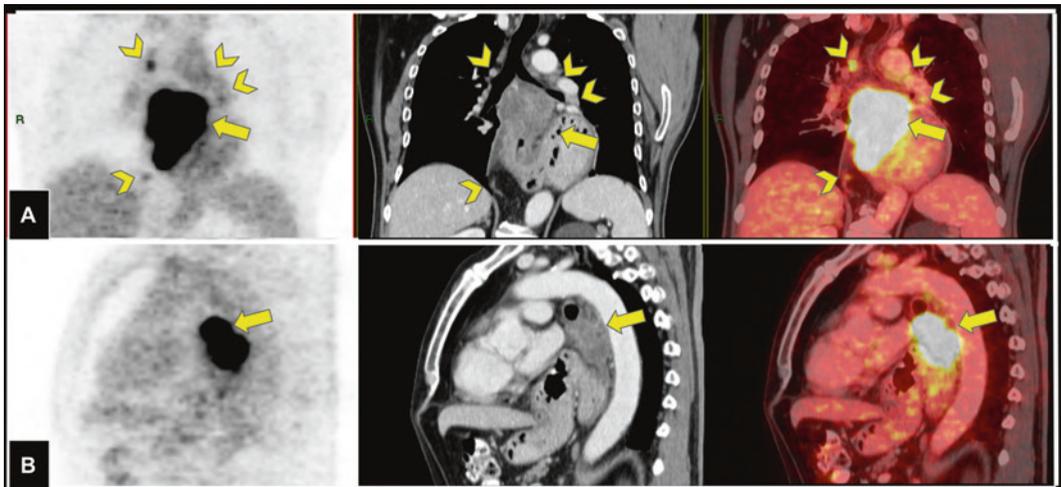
Squamous cell carcinoma in upper third of the esophagus (T3N1M0). A) PET-CT coronal reconstruction demonstrates esophageal hypermetabolic wall thickening preserving peripheral fat (T3, arrow) and two
